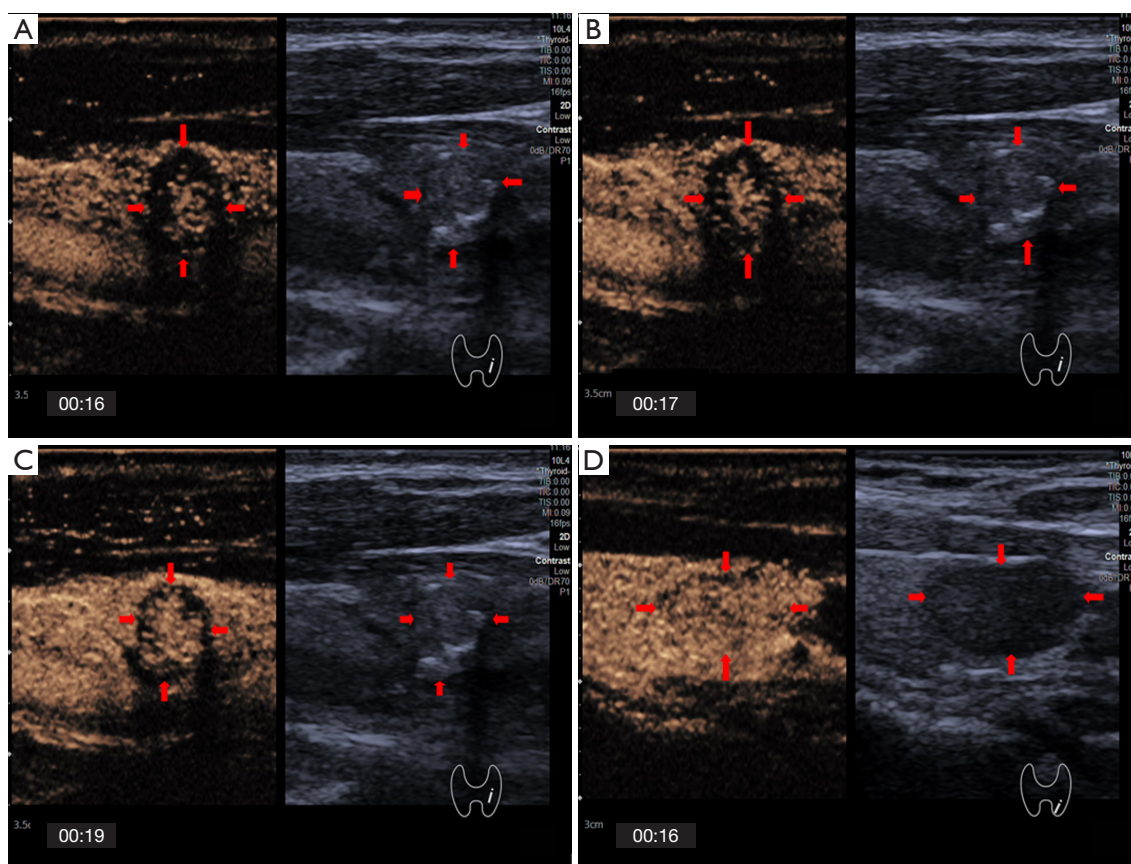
Enhancement direction on CEUS. (A-C) Images of centrifugal enhancement of the same PTC nodule (red arrows) in the left lobe of the thyroid gland of a 69-year-old man. (D) A case of a benign nodule (red arrows) in the left lobe of the thyroid gland of a 65-year-old woman showing the feature of scattered enhancement on CEUS. The minutes and seconds after the contrast media injection are indicated by the numbers in the bottom left corner of each panel. CEUS, contrast-enhanced ultrasound; PTC, papillary thyroid carcinoma.
